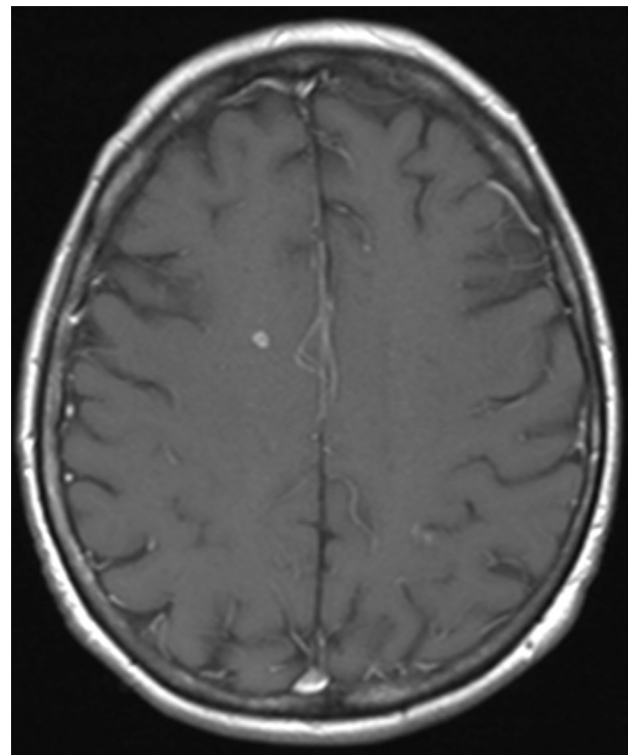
Brain magnetic resonance imaging in March 2014. T1-weighted image after gadolinium of the brain shows a small right frontal enhancing cerebral lesion.
